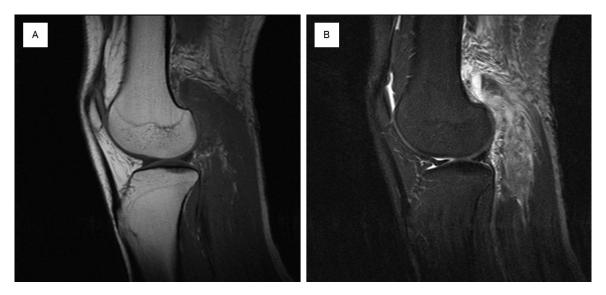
MRI scans of the mass located in the popliteal fossa. A. T1-weighted MR images revealed an isointense lesion mixed with heterogeneous signal intensity. B. T2-weighted images demonstrated a high signal intensity lesion.
